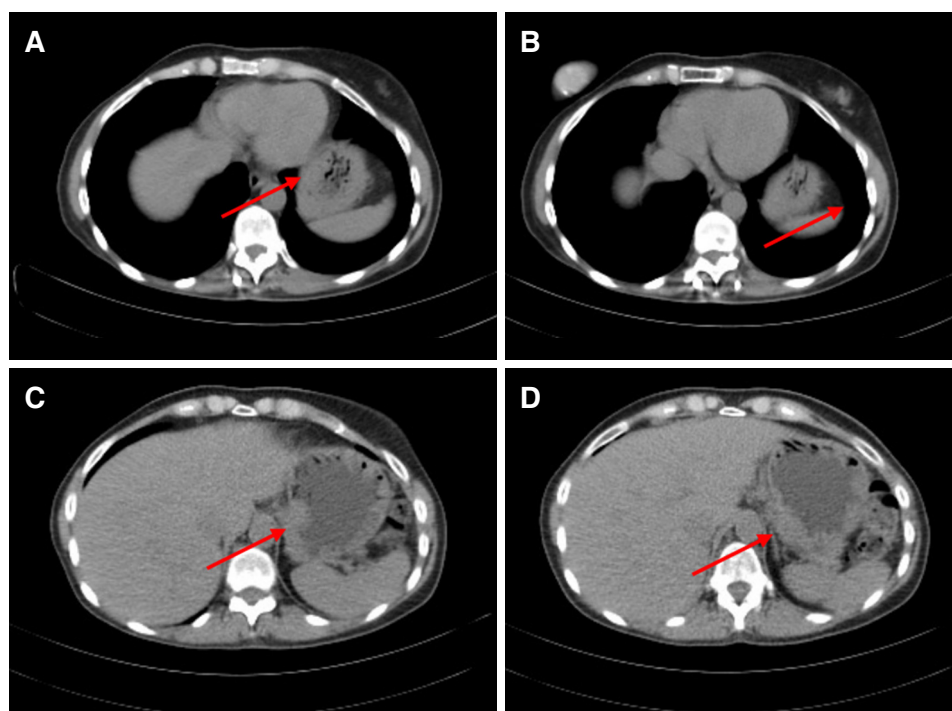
CT scan showing gastric wall thickening at gastric fundus (A-D)
